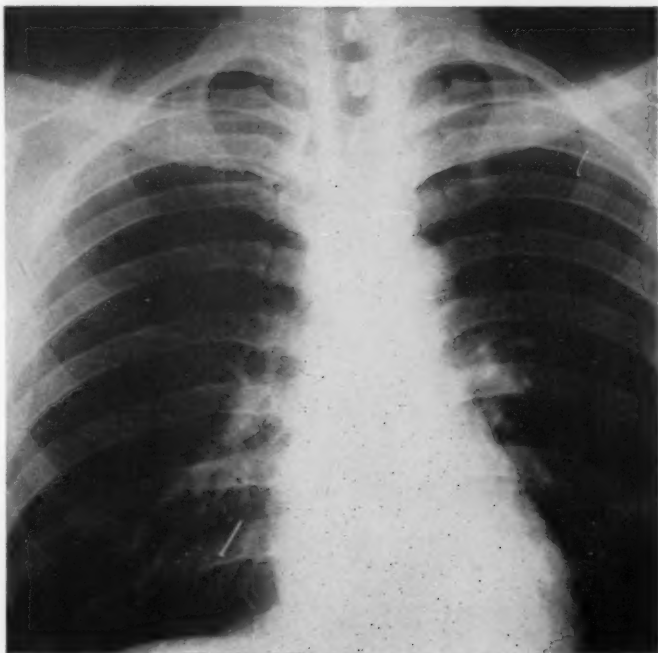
Escutcheon nail in the posterior basal segment of the right lower lobe bronchus. Postero-anterior roentgenogram.
